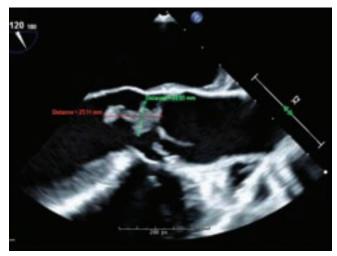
Transesophageal echocardiogram confirmed the presence of a mobile echodensity on the ventricular aspect of the aortic valve.
